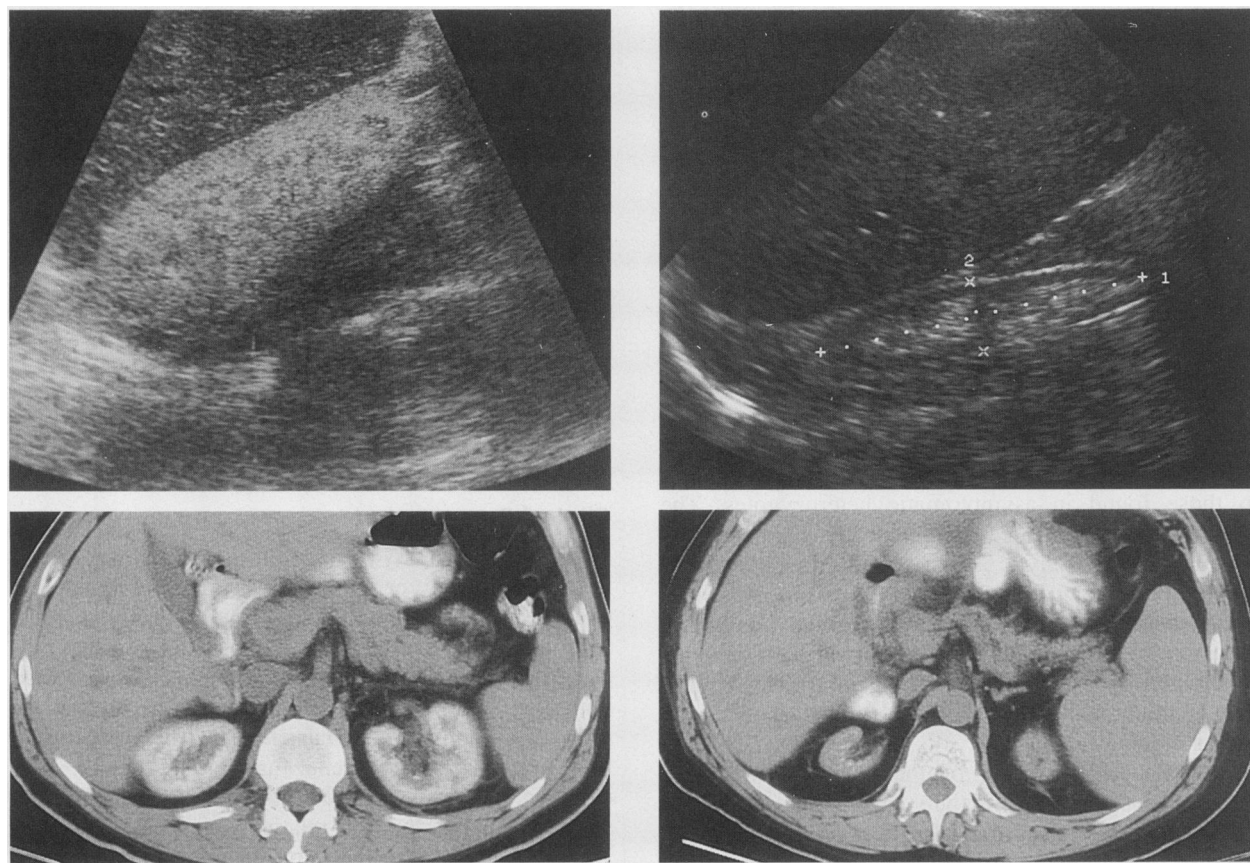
Top left, A right renal ultrasonogram done in January 1991 showed the kidneys to be normal size and highly echogenic. Top right, A renal ultrasonogram done in December 1992 showed an atrophied right kidney with an echolucent cortex. Bottom left, Abdominal computed tomographic imaging without intravenous contrast was done in April 1991 and (bottom right) in August 1992. This imaging documented a reduction in renal cortical calcium oxalate deposition as well as renal atrophy after hepatic and renal transplantation in July 1991.
